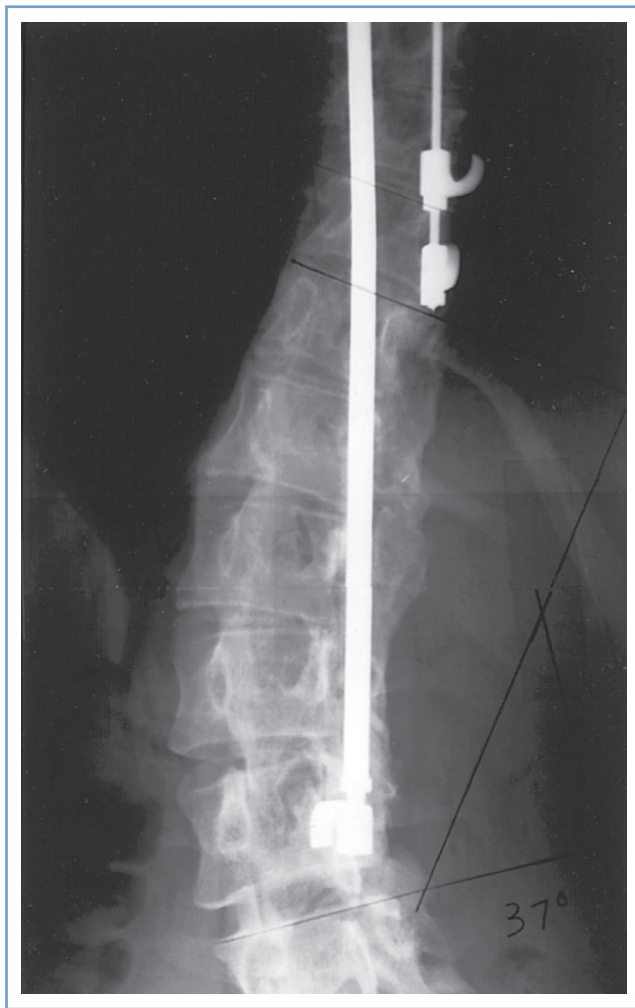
■ Harrington rod instrumentation. Radiographic study of the lumbar spine in a 31-year-old woman with thoracolumbar scoliosis corrected with spinal instrumentation. There is rotation of the vertebrae into the curve (toward the rod), and extensive bone grafting is evident adjacent to the rod. Two lumbar interspaces (L4 to L5 and L5 to S1) are not involved in the fusion.
